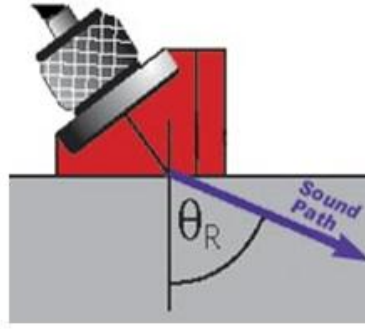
Typical structure of an edge ultrasonic transducer [71]
